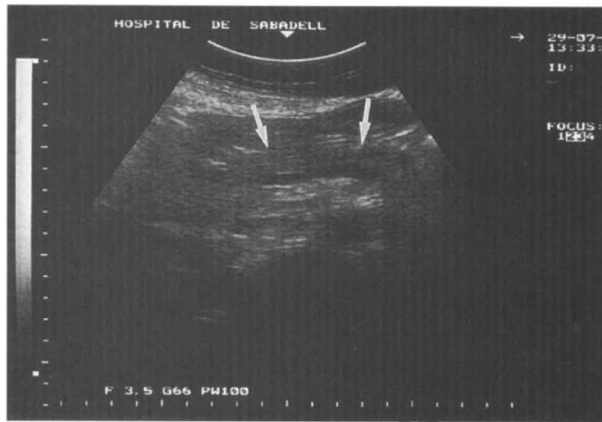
Ultrasonographic transverse scan at the epigastric level. Top. Low ecogenicity of the pancreatic parenchyma (arrows). Bottom. Normal ecogenicity of the pancreatic parenchyma (arrows).
